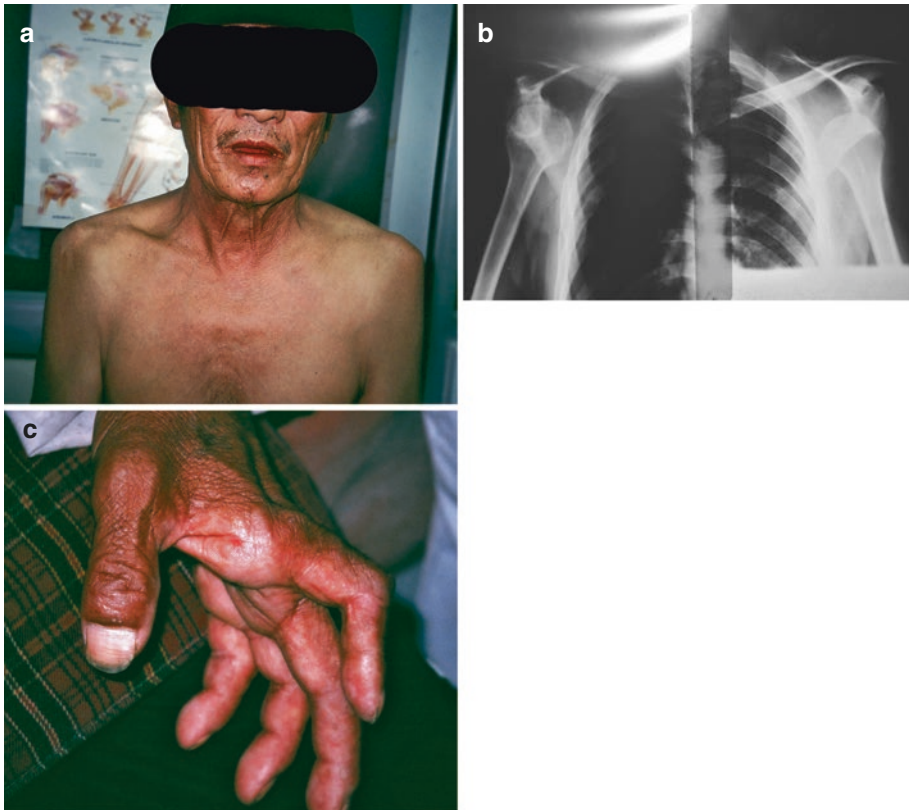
(a) This farmer fell out of a tree in his orchard 6 weeks before and sustained right and left anterior shoulder dislocations. (b) Shoulder X-rays. He came to the orthopedic clinic because he was having some difficulty doing his farm work due to limited motion, and traditional
